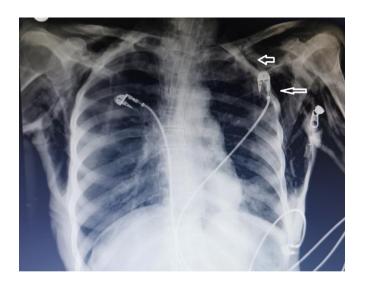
Direct chest radiography of subcutaneous emphysema.
